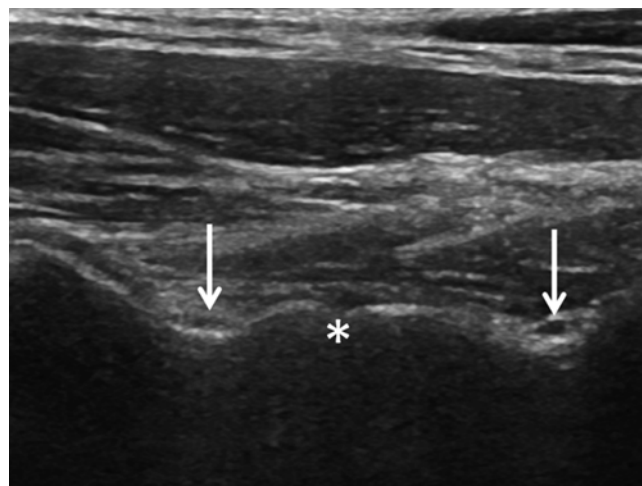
Ultrasound anatomy of the cervical facet joint region cut in a longitudinal plane. * facet joint cleft. *Arrows* medial branch, which appears as a hypoechoic oval structure located in the middle of the “groove” between two facet joints. (With permission of Dr. Andreas Siegenthaler)
